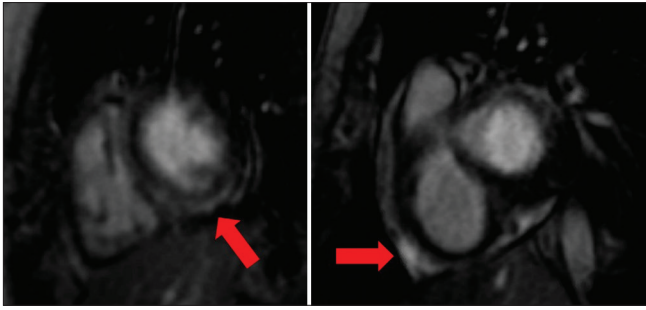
Cardiac magnetic resonance imaging: Normal biventricular size and systolic function with myocardial edema and delayed myocardial gadolinium enhancement in the basal anterolateral and inferolateral segments of the left ventricle (red arrows)
